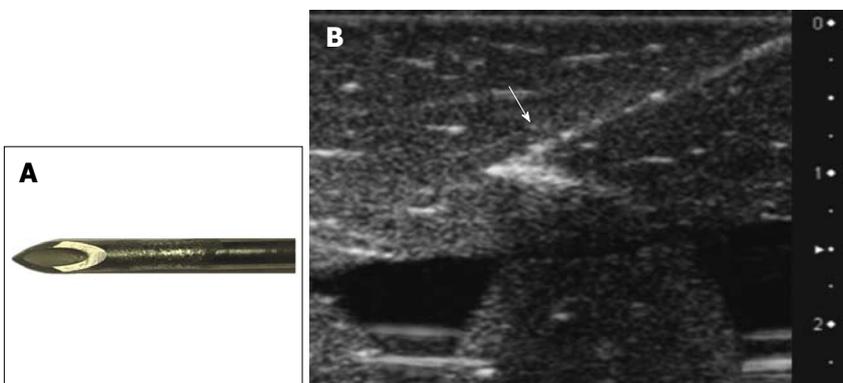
Vascular needle with a rough-filed surface at 3-6 mm from the tip of the needle. A: Needle tip, shaft; B: Corresponding ultrasound image, with the rough surface indicated by the arrow.
